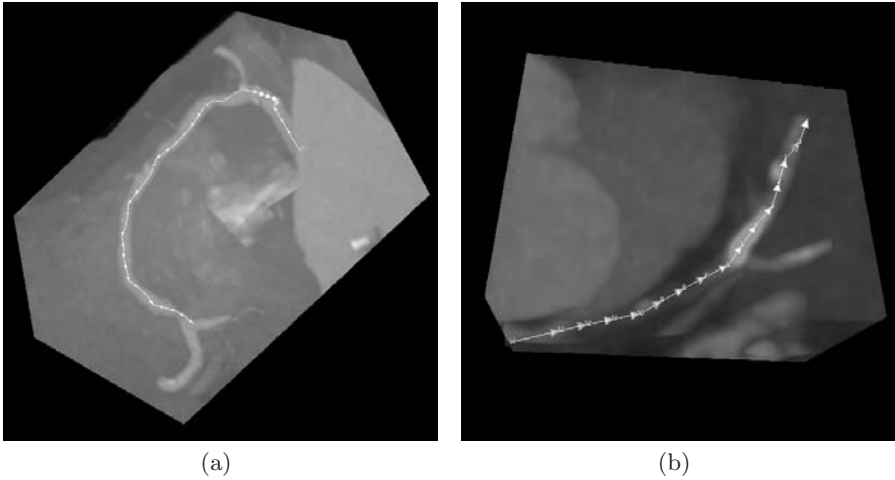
Examples of clinical applications of the probabilistic tracking algorithm. (a) shows a tracked right coronary artery in a CTA dataset. In (b) it is shown that an artery with a chronic total occlusion (CTO) in a CTA dataset is successfully tracked.
